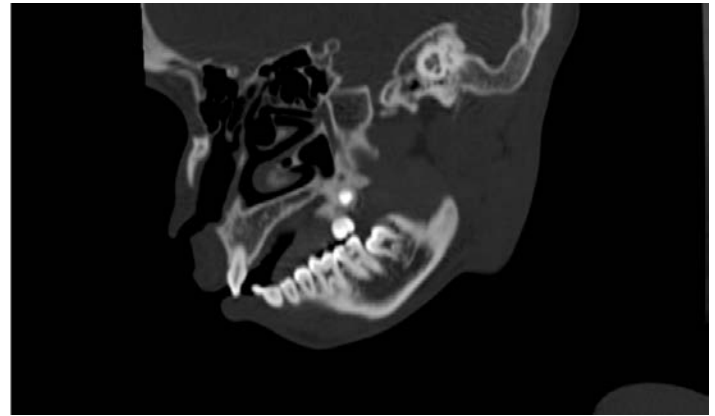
3D CT scan imaging of third molar.
